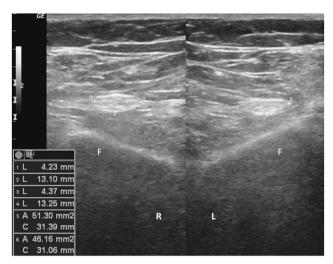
Bilateral ultrasonographic imaging (axial view, mid-thigh) of the sciatic nerves demonstrating the measurements of short axis, long axis and cross-sectional areas. F, femur; L, left; R, right.
